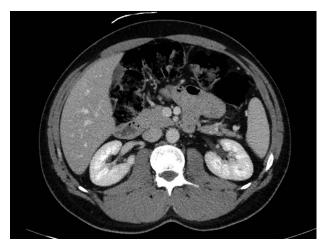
A contrast enhanced Axial computed tomography image of the abdomen showing complete resolution of the retroperitoneal mass after 12 month of treatment.
